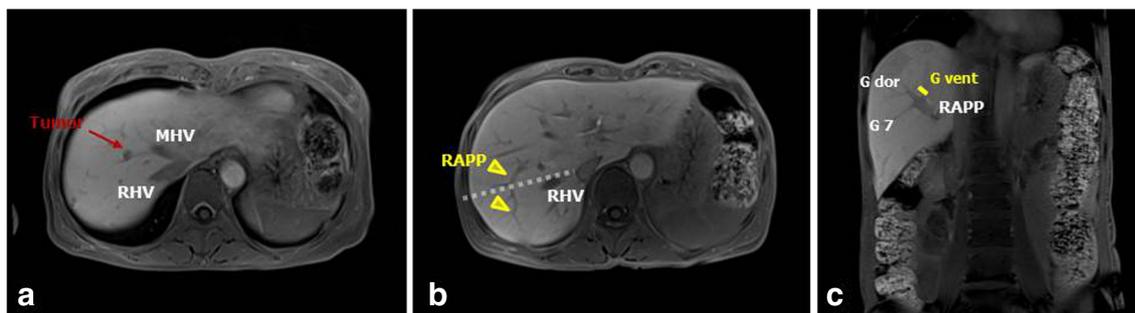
Preoperative liver MRI. a The metastatic tumor was located in the ventral area, and a 7-mm tumor was found to be invading segment 8 hepatic vein. b Some branches of the right anterior portal pedicle (yellow arrowheads) crossed over to the right hepatic vein. c Regarding the ramification pattern of right anterior section, the ventro-dorsal type
